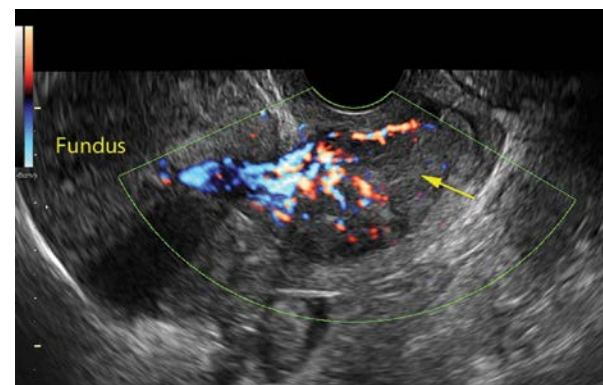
(a) Transvaginal sagittal view of an anteverted uterus containing a submucosal fibroid (arrows). Note the splaying of the echogenic endometrial echo around the hypoechoic solid fibroid. Vascular flow is shown by Doppler. (b) 3D rendering of the endometrial cavity showing the fibroid protrudes into the cavity and is attached by a stalk (arrows).
